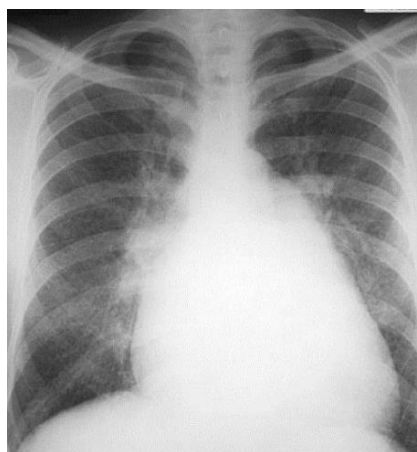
Chest X-ray revealed prominent cardiomegaly with pulmonary congestion
